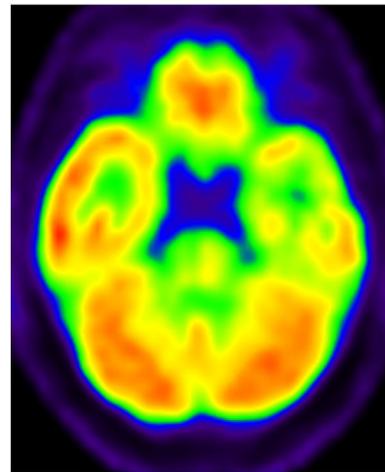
FDG-PET with hypometabolism on operated side in patient with MRI-negative TLE.
